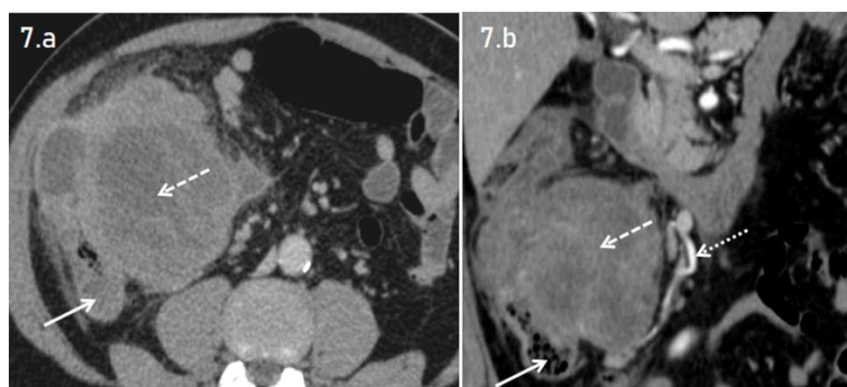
(a & b): 61-year-old case with malignant colonic GIST. Axial (a) and coronal (b) views of contrast-enhanced CT study of abdomen in venous show a large, exophytic heterogeneously enhancing lesion with central necrosis (dashed arrow) is seen arising from the medial wall of ascending colon (solid arrow). The lesion is seen compressing the ascending colon causing severe luminal narrowing. A prominent arterial feeder (dotted arrow in b) is seen arising from the superior mesenteric artery.
